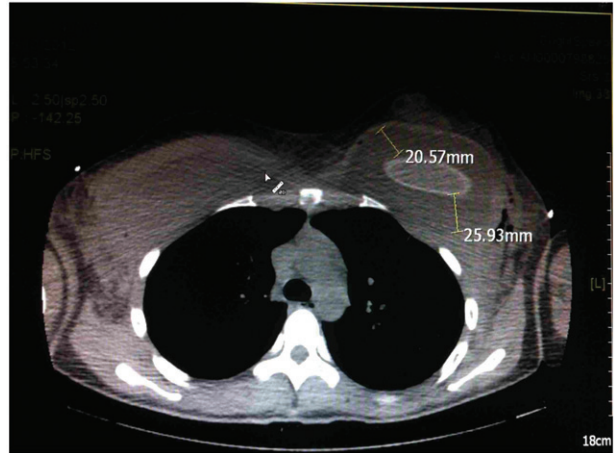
CT scan revealed the presence of haematoma with greatest dimensions of 20.57 mm and 25.93 mm.
